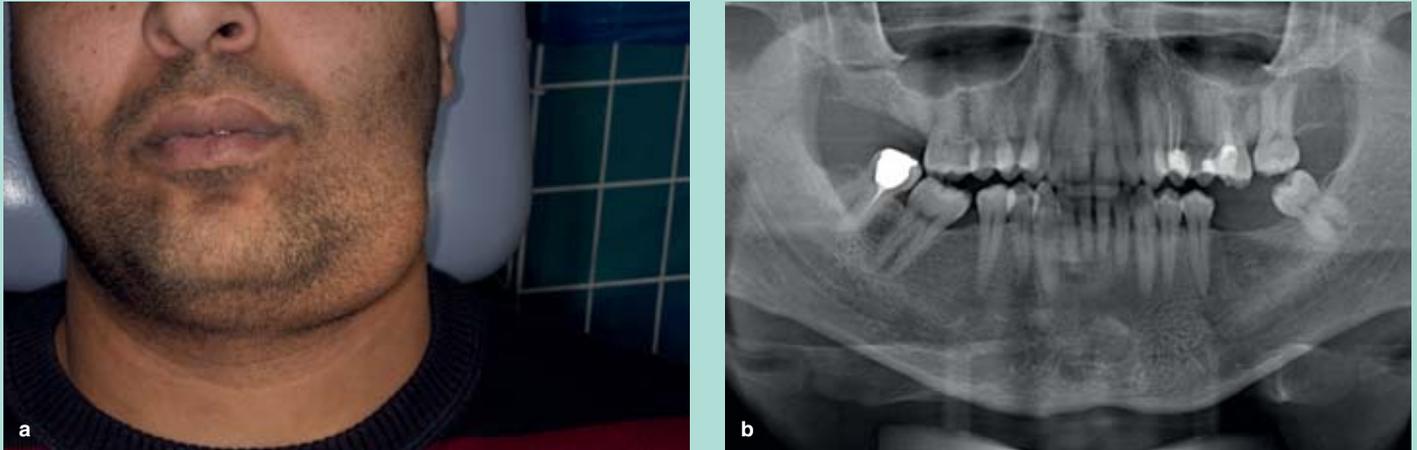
Patient (57 years of age) with unremarkable general past history with an odontogenic infection with risk of propagation (perimandibular abscess) with status post tooth extraction <3 weeks ago: clinical finding of swelling perimandibular left (a); orthopantomogram at the point of hospitalisation (b)
